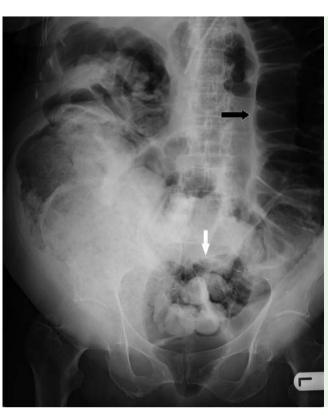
Plain abdominal X-ray showing significantly dilatated large bowel loops (black arrow) proximal to the sigmoid colon stent (white arrow), which appears to remain in a satisfactory position, fully opened out.
